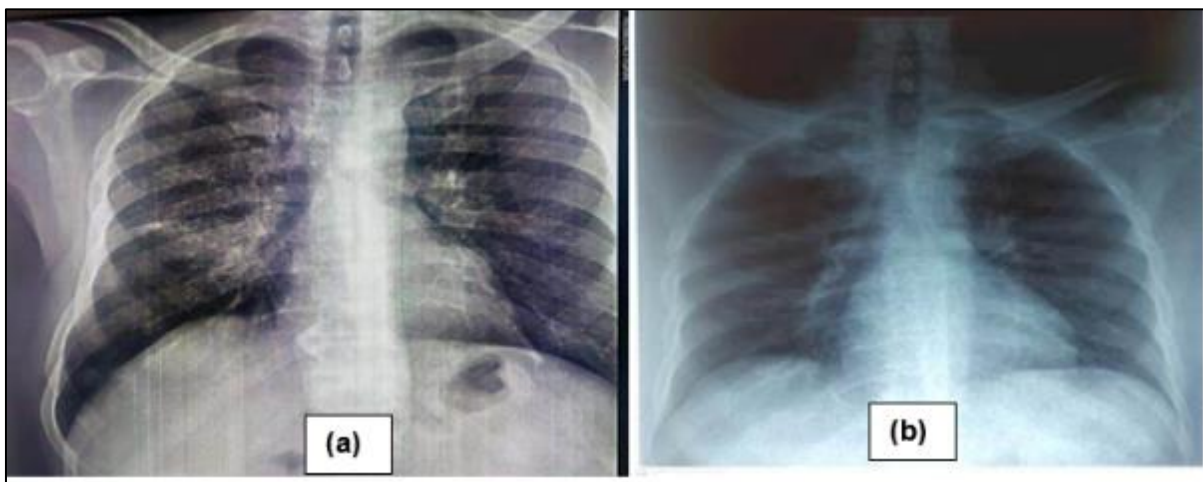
A comparison between a chest X-ray taken upon his admission to the service (b) and a chest X-ray taken two years ago (a) revealed a similar involvement consistent with an interstitial syndrome
